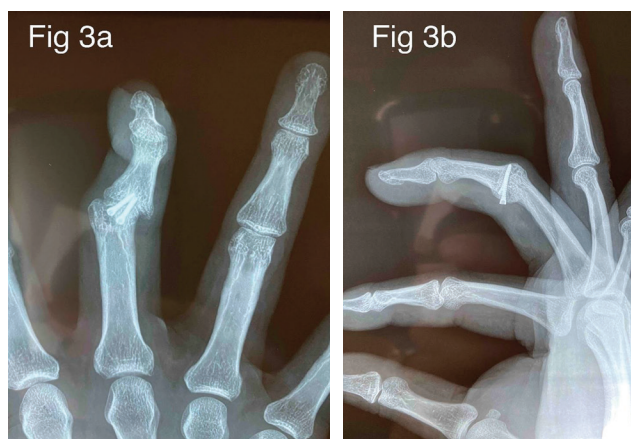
Radiographs showed ulnar deviation of the PIPJ flattening of the head of the proximal phalanx at the ulnar side (A). Lateral radiograph showed stable graft healing (B).
